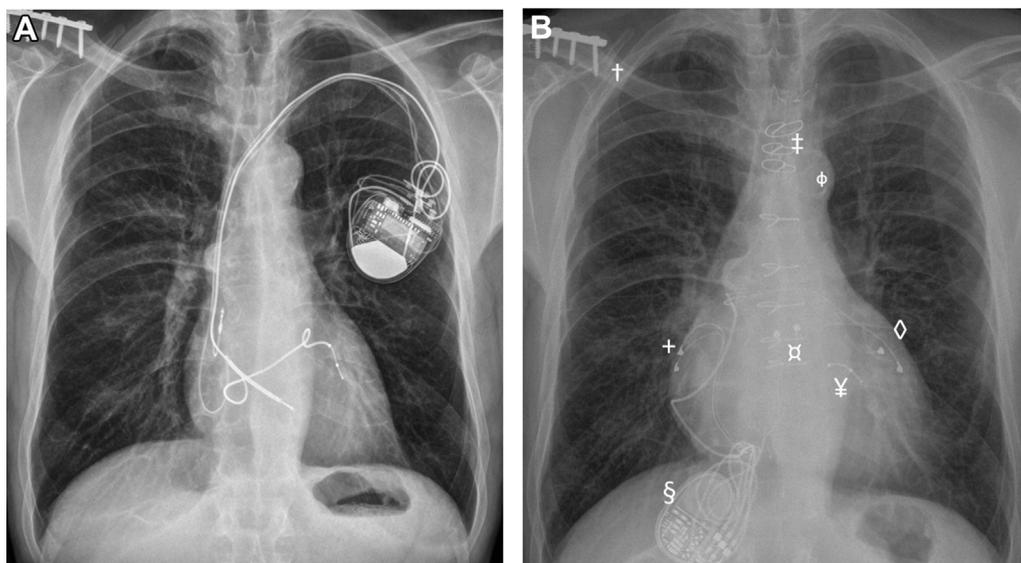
Roentgenogram images with transvenous CRT (A) and epicardial CRT (B). †: Clavicular plaque and screws; ‡: Sternotomy closing wires; Φ: Calcified aortic arch; +: Epicardial right atrial lead; ♂: Epicardial right ventricular lead; ¥: Coronary sinus lead remnant; ◇: Epicardial left ventricular lead; §: Pacemaker generator.
